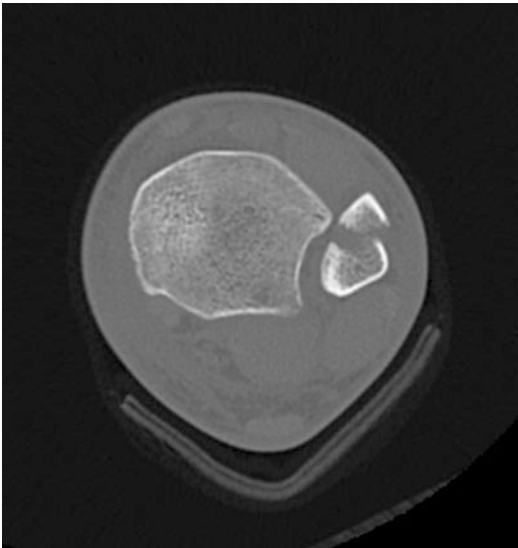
Computed tomography of the distal tibiofibular joint. Sagittal dislocation of the tibiofibular joint is shown
